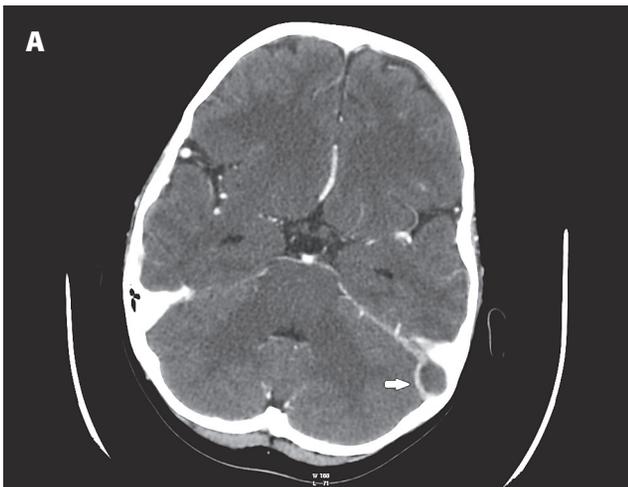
Angio-CT (A) axial plane, (B) coronal plane. Lack of contrast filling in the left sigmoid sinus – thrombus
